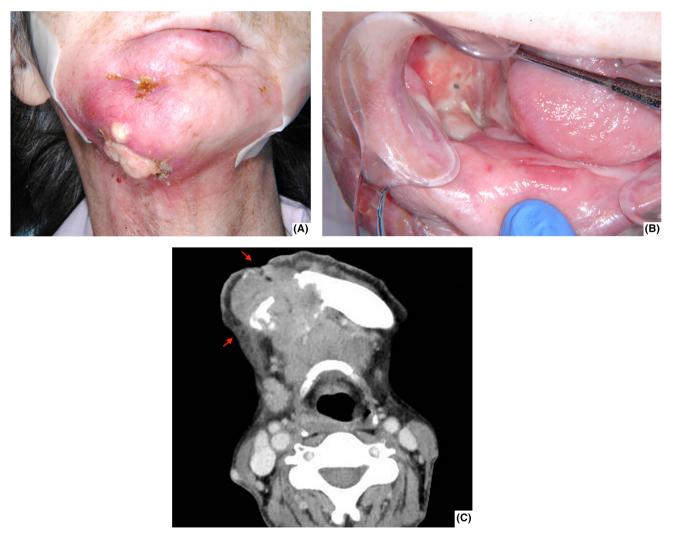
(A, B) A photograph showing the patient's extra- and intraoral appearance after super-selective intra-arterial cisplatin infusion concurrent with intensity-modulated radiation therapy (C) contrast-enhanced axial CT showing residual tumor in the mandible (arrows) after concurrent chemoradiotherapy.
